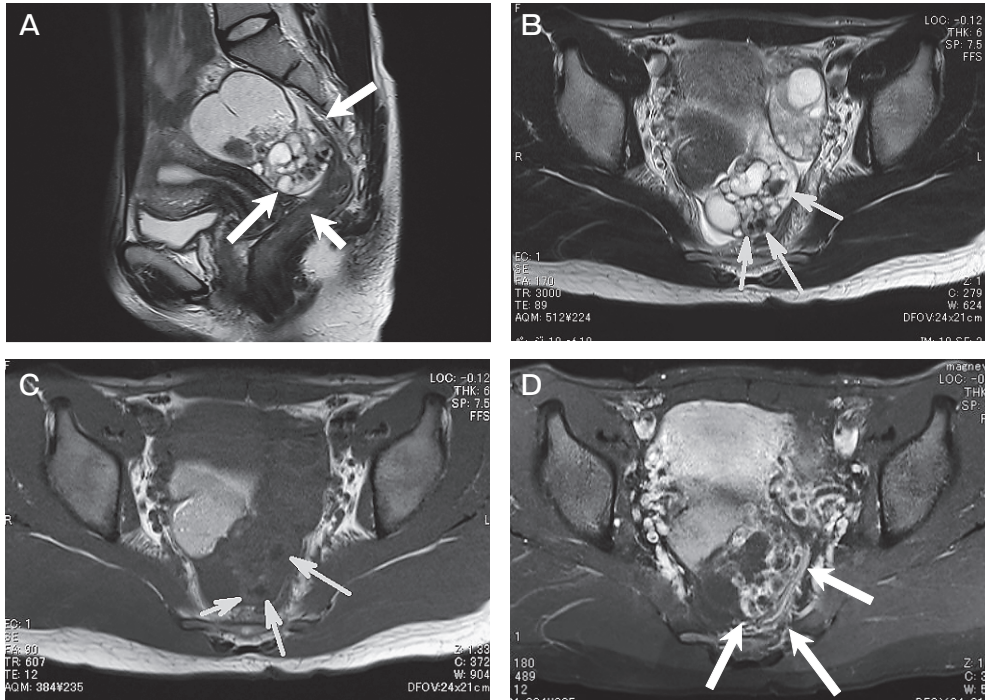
(case 2): Pelvic MRI shows multiple small cysts with thick septations, some of them filled with colloidal material which show as low signal density in both T2- (A, B) and T1- (C, D) weighted images. arrow, ovarian tumor.
